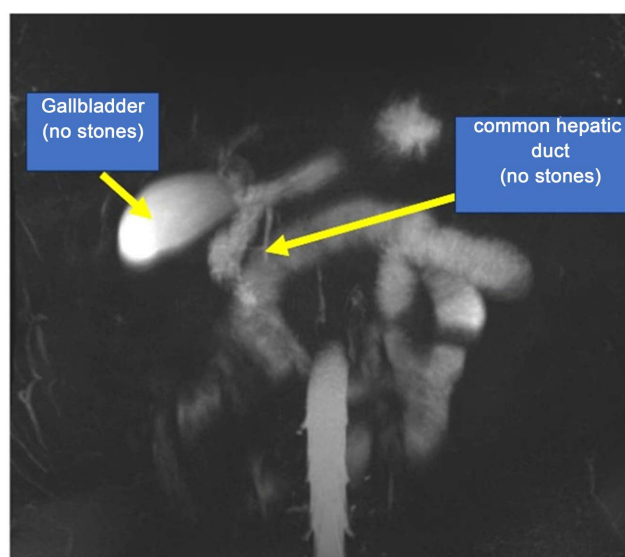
Magnetic resonance imaging (MRI) showing the absence of biliary lithiasis.
